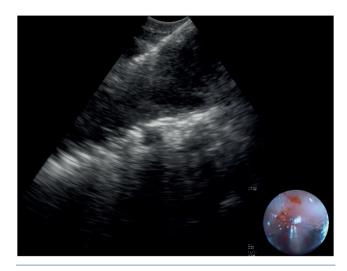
Transbronchial needle aspiration in the mediastinal lymph node through endobronchial ultrasound bronchoscope.
